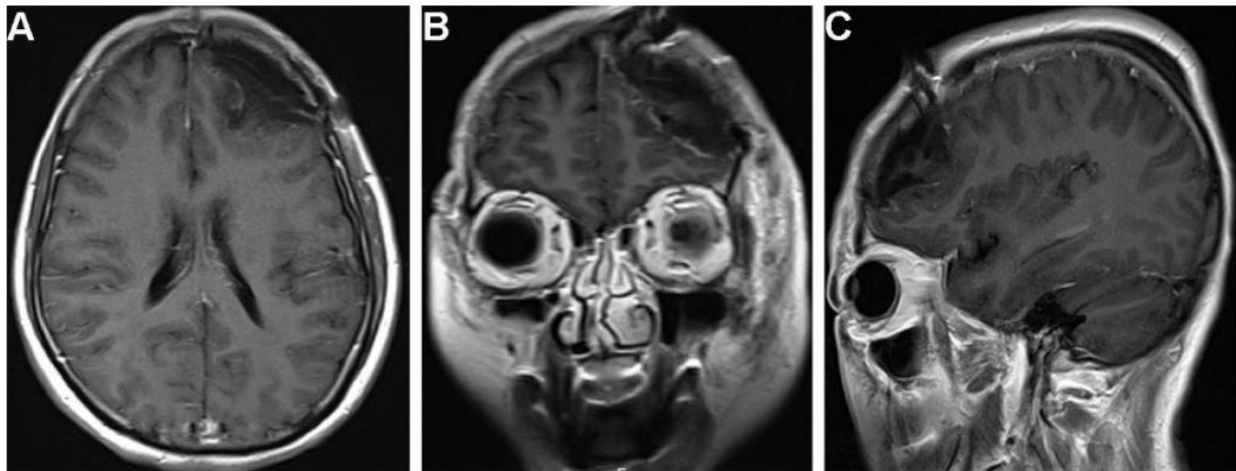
postoperative head MRI with gadolinium enhancement: axis (A), coronal (B), sagittal (C)
